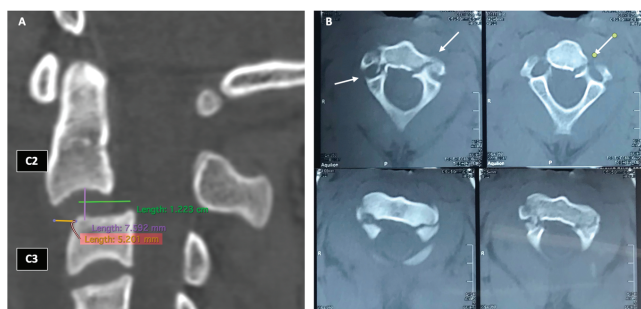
Cervical CT Scan. Anterior dislocation of the vertebral body C2 to the vertebral body C3 with the length more than 5 mm (A); Axial CT scan showing bilateral pedicle fracture of the C2 (arrow) without disturbance of the foramen transversarium of the C2.
